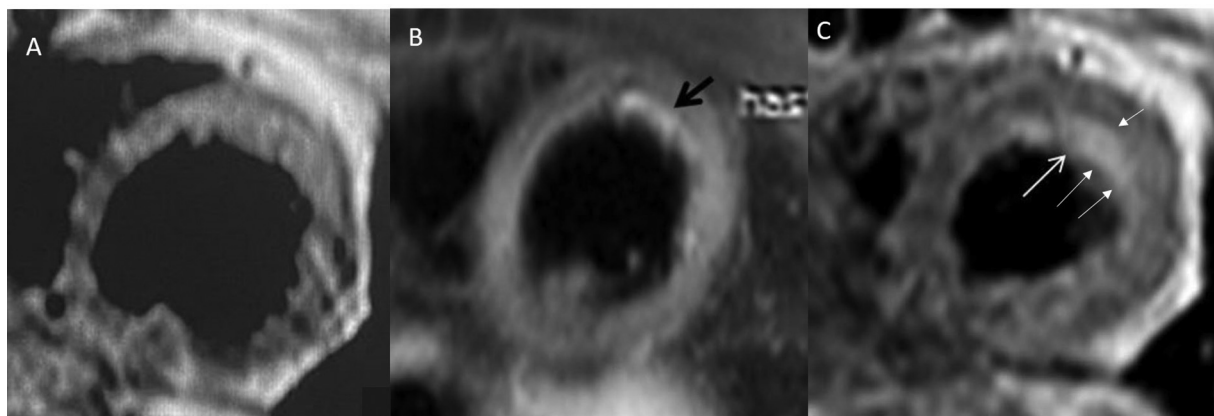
A 48-year-old woman presented with nausea, dyspnea on exertion, difficulty in talking, and chest discomfort, 7 days after receiving her first dose of ChAdOx1 vaccine. (A) Magnetic resonance imaging (MRI) short-axis T1 image, (B) fat-suppressed T2 image, and (C) T1 image obtained after 10 minutes of contrast administration show T2 hyperintensity in the subendocardial region (*black arrow*) and subendocardial and mid-myocardial delayed postcontrast enhancement (*white arrows*) in the anterolateral part of the left ventricle suggestive of myocarditis.
